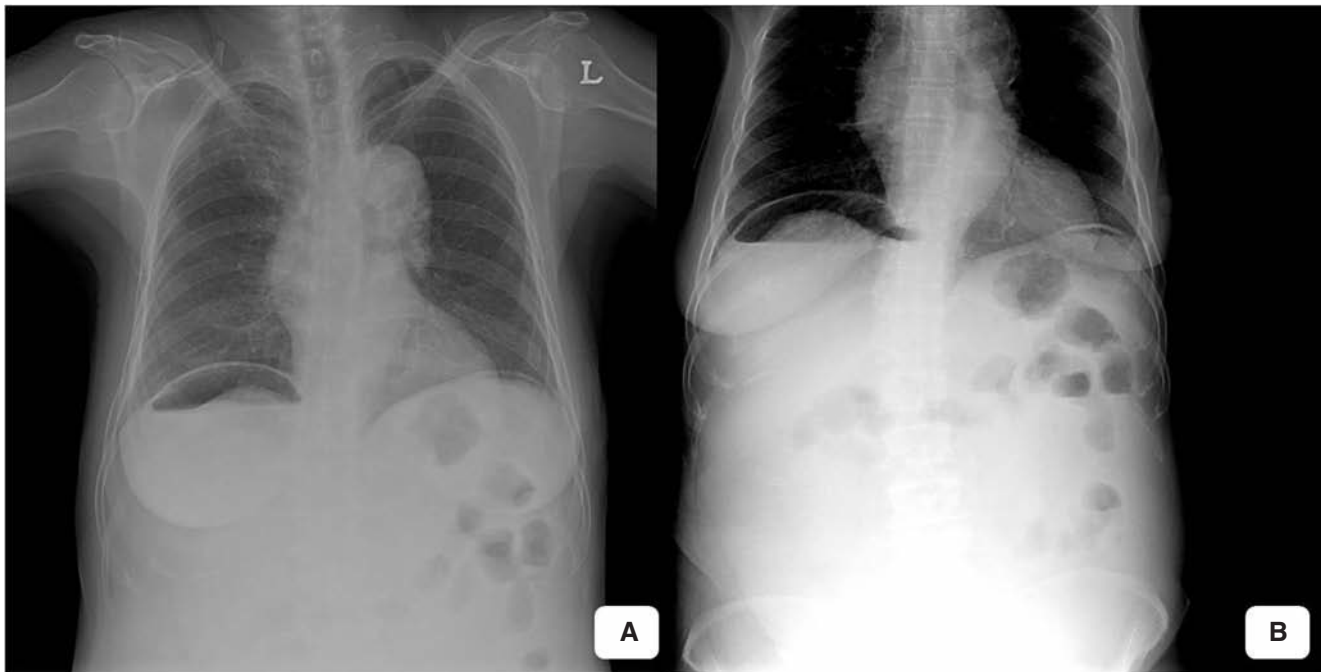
Posteroanterior chest and abdominal erect x-ray. There is free gas under the diaphragm in both views.
